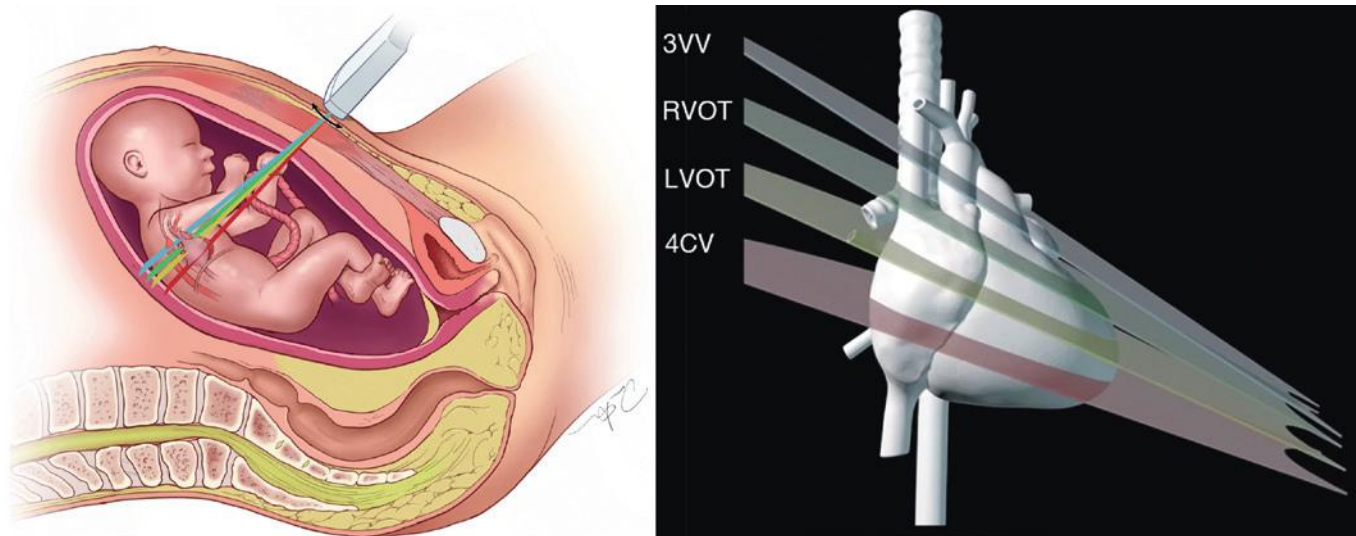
Basic sonographic approach for the midtrimester fetal cardiac screening examination. Cephalad sweep of an ultrasound transducer toward the fetal head is used to visualize a four-chamber view (4CV), left ventricular outflow tract (LVOT), right ventricular outflow tract (RVOT), and three-vessel view (3VV), respectively.
